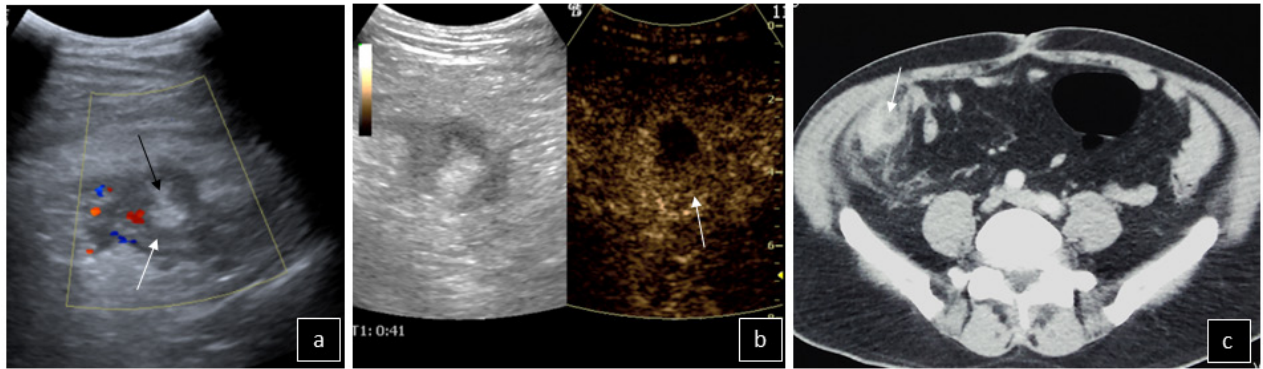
Epiploic appendagitis: A mixed echogenicity lesion is noted on colour Doppler US (a) in the right iliac fossa. It shows increased peripheral flow and a hypoechoic halo (white arrow), representing inflamed visceral peritoneal covering, surrounding central echogenic fat (black arrow). On CEUS the lesion’s periphery shows rich enhancement (arrow in b). CECT confirms findings and a central hyperattenuating “dot sign”, due to engorged central vessels (arrow in c).
